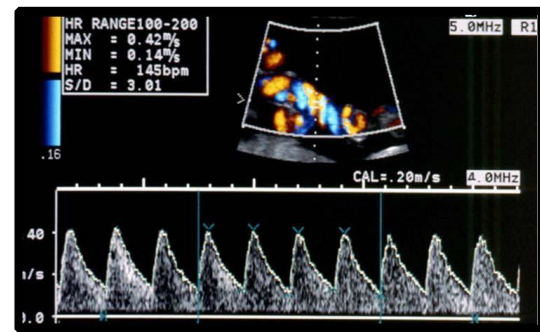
Umbilical artery Doppler waveforms in a normal fetus in the third trimester of pregnancy, shows low impedance circulation with increased end-diastolic velocity [6, 7].
